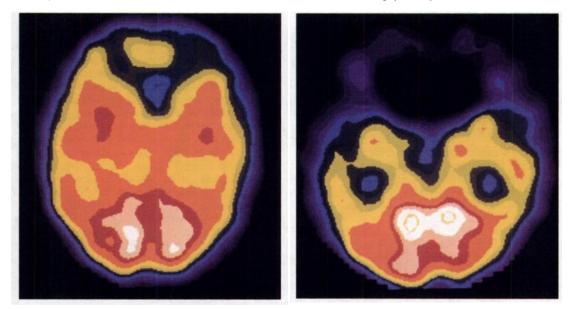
The SPECT rCBF measurements at rest from two FTD patients: (a) the almost normal finding at an early stage with low grade of disability (case 2); (b) the profoundly decreased rCBF in the frontal regions at an advanced stage of dementia (case 16). Higher rCBF levels are shown by red and yellow, and lower levels by dark green and blue colours.
